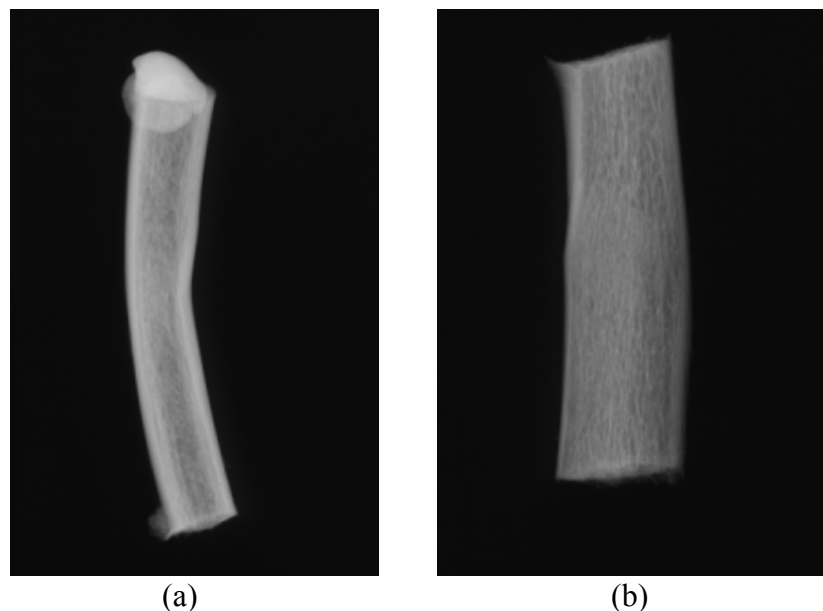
Radiographs of immature full rib bones following mechanical testing (a) cropped region at sight of buckling, posterior to sternal end of rib (b) same region viewed at 90 degrees to first radiograph
